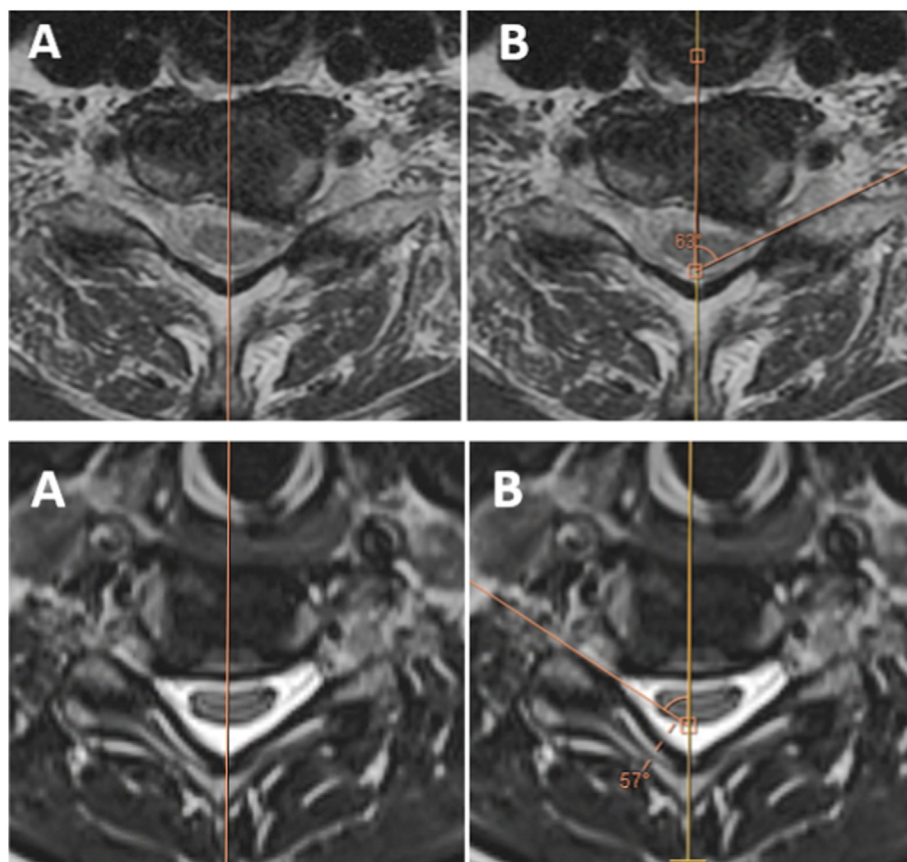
Angle measurement protocol: Axial T2 MRI images at C6/7 for a planned left C6/7 (top) and C5/6 for a planned right C5/6 TFESI (bottom). (A) A sagittal line was drawn using the MRI program software to bisect the disc and spinous process (or midpoint of the lamina). (B) The angle measuring software was used to determine the angle between the sagittal line and the ventral surface of the superior articular process.
